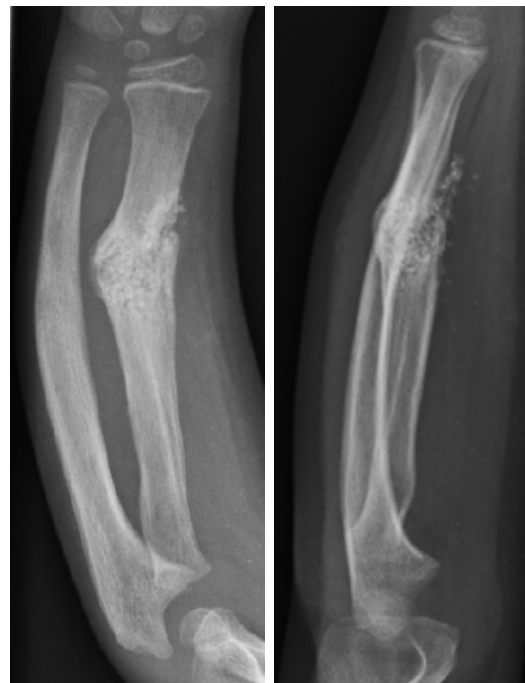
Postoperative radiograph showing excellent packing of the defect with Opteform.
